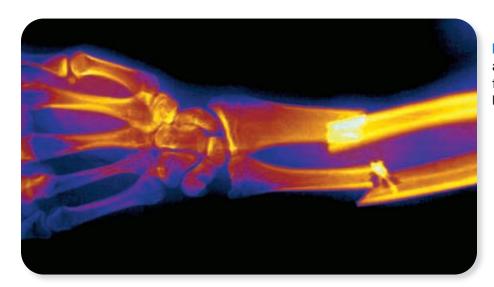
This photo shows an X-ray image of a broken forearm. You can see that both bones are broken.
